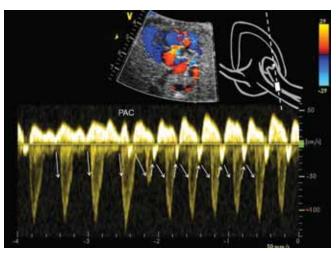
Simultaneous superior vena cava and descending aorta Doppler captures the start of tachycardia with a premature atrial beat
